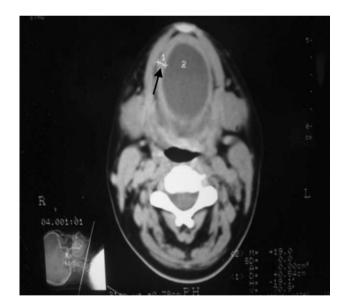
Pre operative CT scan showig thick capsule but not showing much enhancement with I.V contrast and no calcifications were seen
